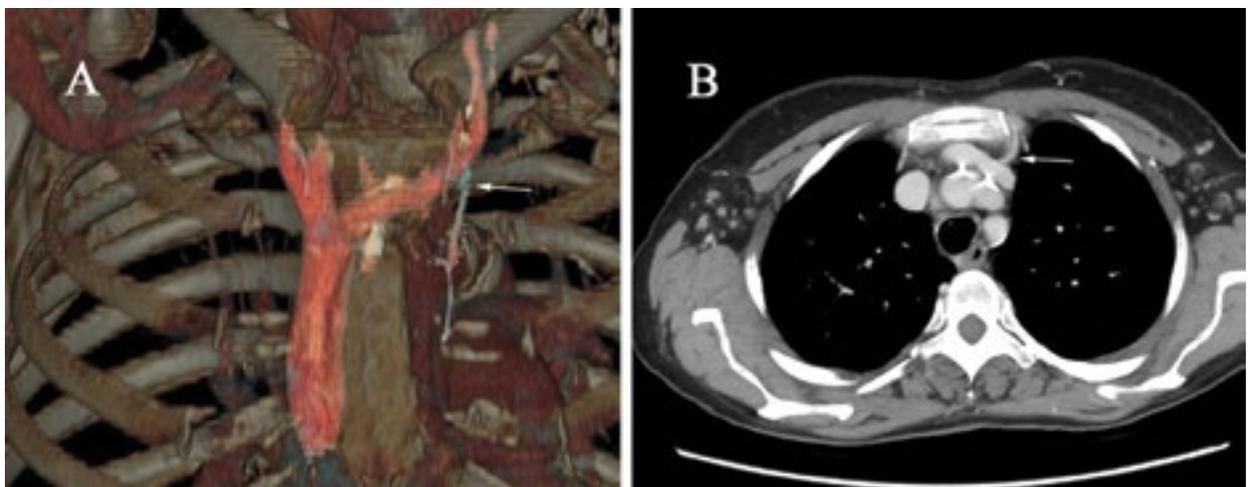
The course of the left internal thoracic (mammmary) vein (IMV) (arrow) and the site where it joins the left brachiocephalic vein (BCV) at the inferior aspect of the curve in the left BCV: A. An anteroposterior (AP) view; three-dimensional (3D) reconstruction: vessel topography in relation to the bony structures of the chest; B. An axial computed tomography (CT) view: the segment of the left IMV (arrow) that joins the left BCV shown in relation to the anterior thoracic wall
